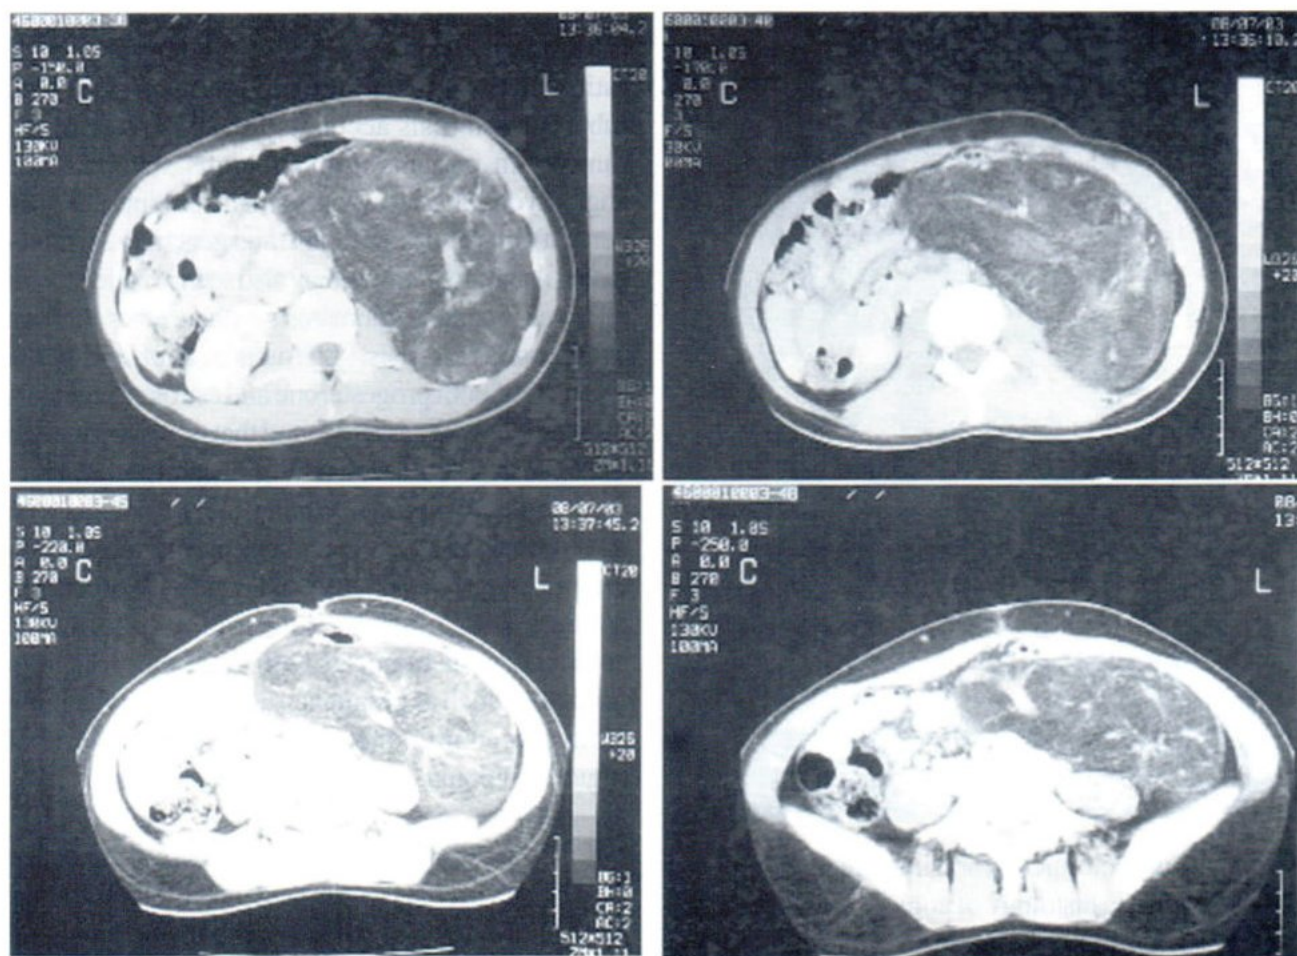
Contrast-enhanced CT scan of the abdomen shows a large well demarcated fatty tumor in the left retroperitoneum, surrounding and displacing left kidney upward and anteriorly with sharp defects in the renal parenchyma (arrow) and additional multiple small fatty tumors at lower pole of left kidney.(curve arrows)
